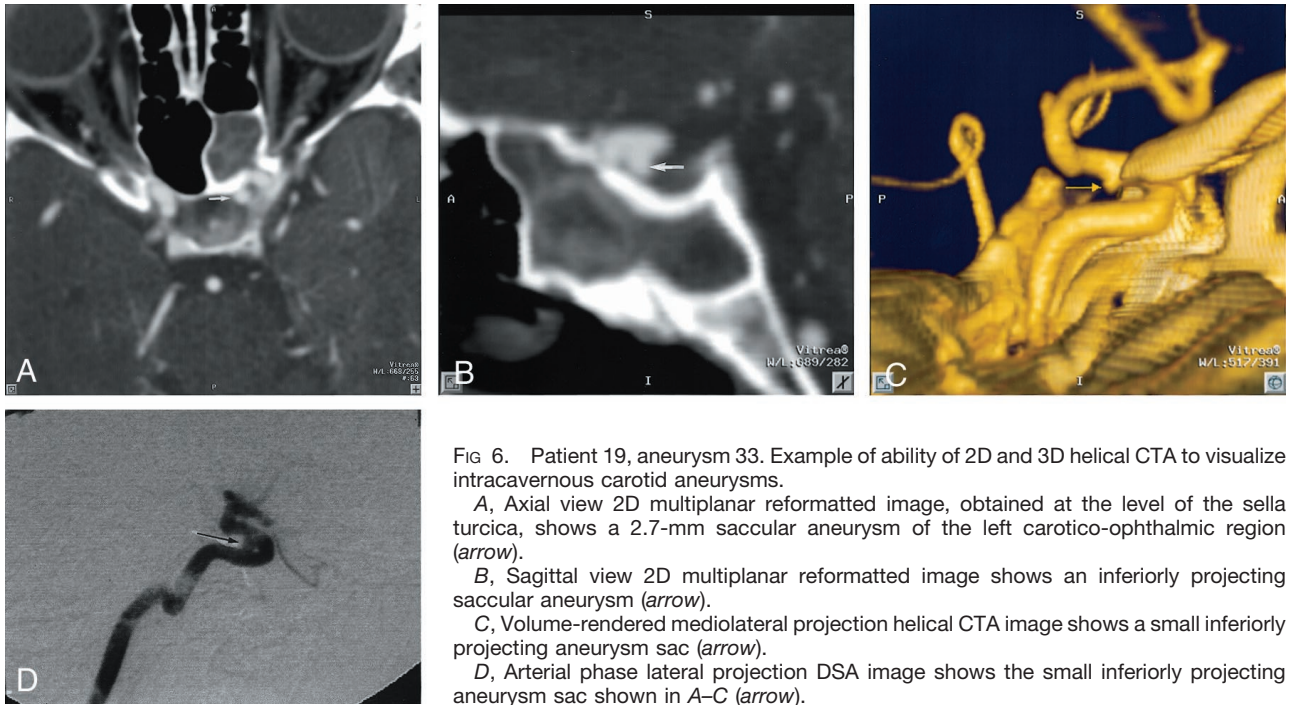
Patient 19, aneurysm 33. Example of ability of 2D and 3D helical CTA to visualize intracavernous carotid aneurysms.
